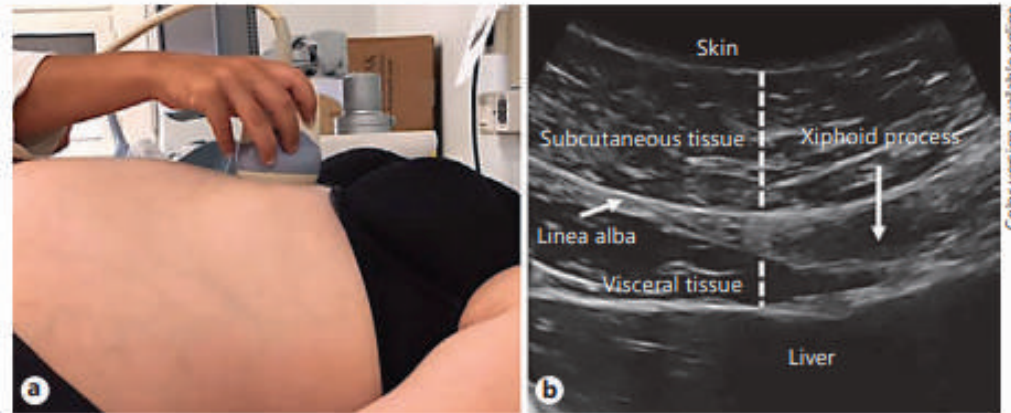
Images showing the correct placement of the ultrasound transducer on the maternal abdomen (a) and the measurement of subcutaneous and visceral adipose thickness (b).
